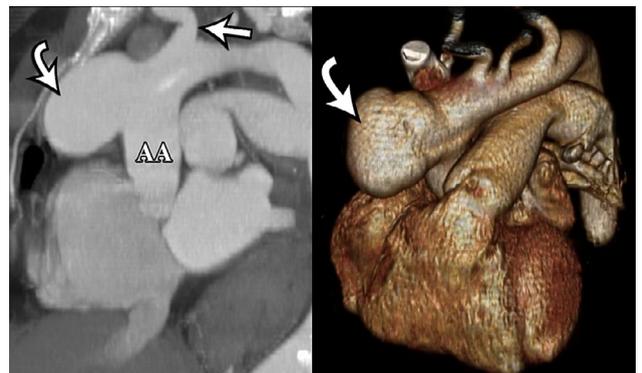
A computed tomography view (left) of the aneurysm in the ascending aorta (AA) aneurysm (left arrow) and a 3-dimensional volume rendering (right) derived from computed tomographic angiography. The off-axis oblique sagittal maximal intensity projection demonstrates the focal, saccular pouching-out (curved arrow) with a narrowed neck originating from the anteriolateral aspect of the mid tubular ascending aorta proximal to the origin of the innominate artery (straight arrow).
